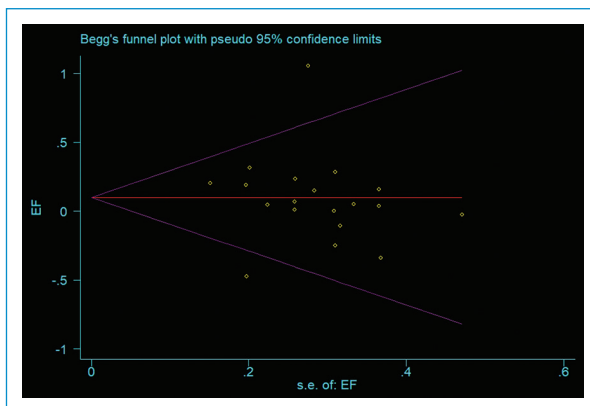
Funnel plot of publication bias for EF (MRA vs. CTA), Begg's p 0.208.
